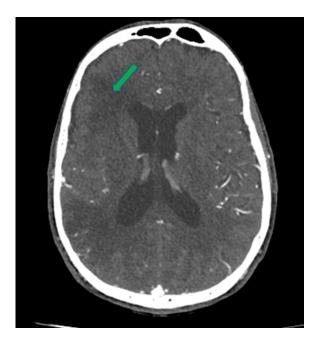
Axial section of a brain CT scan in the parenchymal window, after injection of contrast medium, showing hypodense cortico-subcortical areas in the right frontal and temporo-occipital region, about a right total Sylvian ischemic stroke (Green arrow) (Color version of figure is available online)
